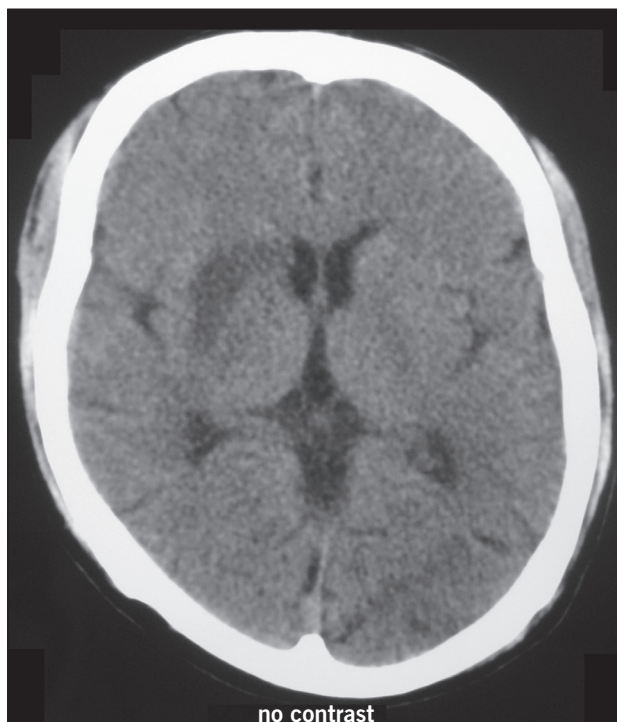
Computed tomography (CT) shows hipodensity in the basal ganglia.
